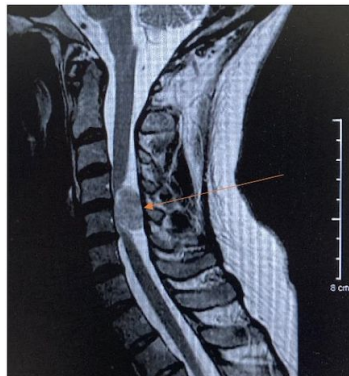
Sagittal view from cervical MRI showing mass lesion compressing spinal cord
